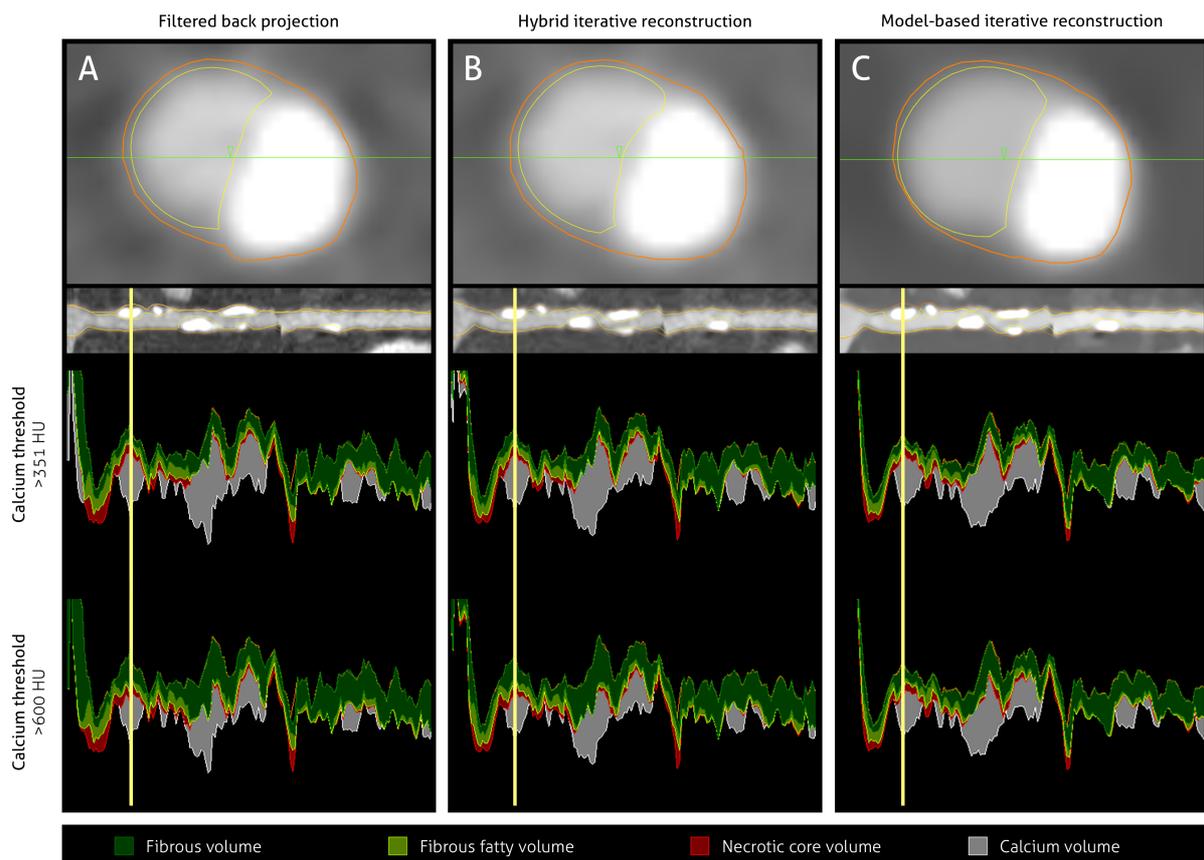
Low-dose coronary computed tomography angiography images (upper two rows) and corresponding volume graphs at two calcium thresholds (>351 and >600 Hounsfield units) with larger calcium-volumes at a threshold of >351 Hounsfield units. Images were reconstructed with filtered back projection (A), hybrid iterative reconstruction (B) and model-based iterative reconstruction (C)
